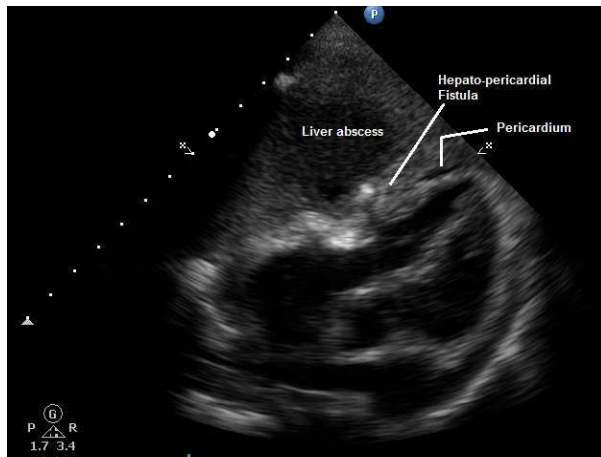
Echocardiography (post drainage scan) showing liver abscess, pericardium (white turned line) and hepato-pericardial fistula (white line)
